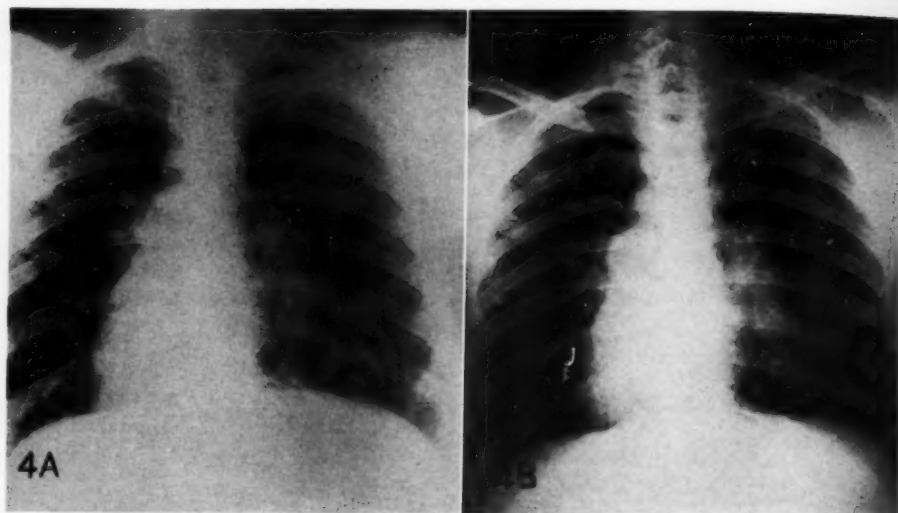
Reproduction of 4 × 5-inch photograph of the fluoroscopic image. Particularly when studied stereoscopically the hilar lymph nodes appeared large and discretely margined. B. Reduction reproduction of a 14 × 17-inch roentgenogram of the same case. With this latter technic the hilar lymph nodes were not nearly so conspicuous. In proportion to the diameters of the thorax they appeared to be only slightly enlarged and their outlines were rather hazy. Thus, the reduction provided in photographing the fluoroscopic image served to sharpen even the distorted image.
